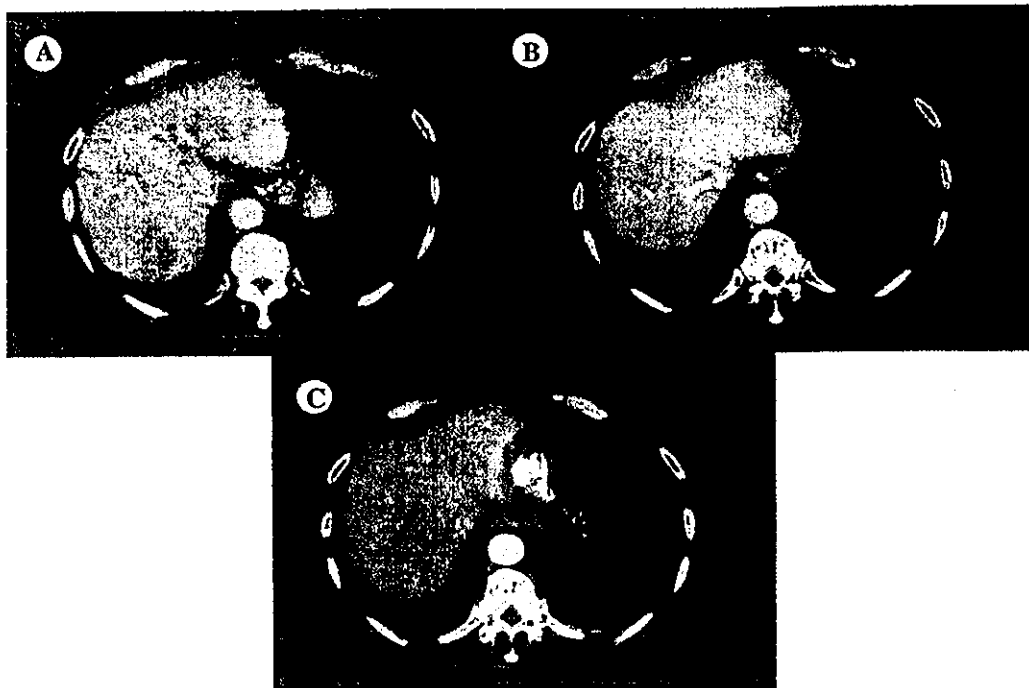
Contrast-enhanced CT before (A, early phase; B, late phase) and after LELI-RFA (C) for HCC (3 cm) located in the S2 region of the liver. The HCC was located close to the heart, which made it difficult to insert the RFA electrode through a percutaneous approach even under the US guidance. Therefore, LELI-RFA was chosen for the treatment. The lipiodol-deposit corresponded to the entire tumor region and the low-density area is seen around the lipiodol-deposit.
